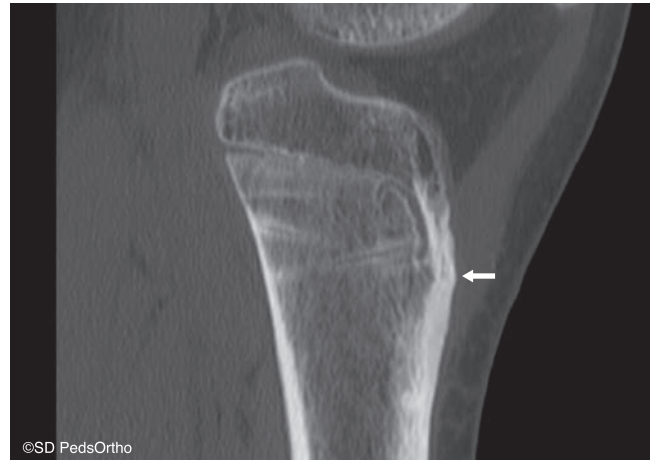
Sagittal CT scan at 1 year post-reduction and smooth wire fixation of a 12-year-old tibial tubercle fracture (San Diego type A) with subsequent physeal bar formation (*arrow*) and developing genu recurvatum.
